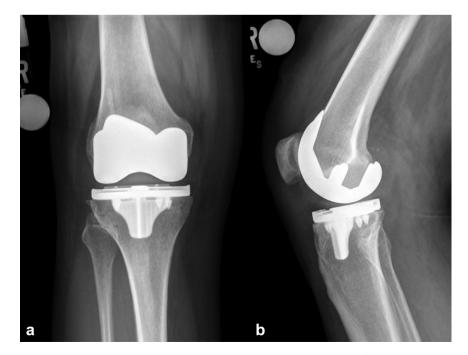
Four-week postoperative (a) AP and (b) lateral radiographs demonstrating press-fit total knee arthroplasty.
